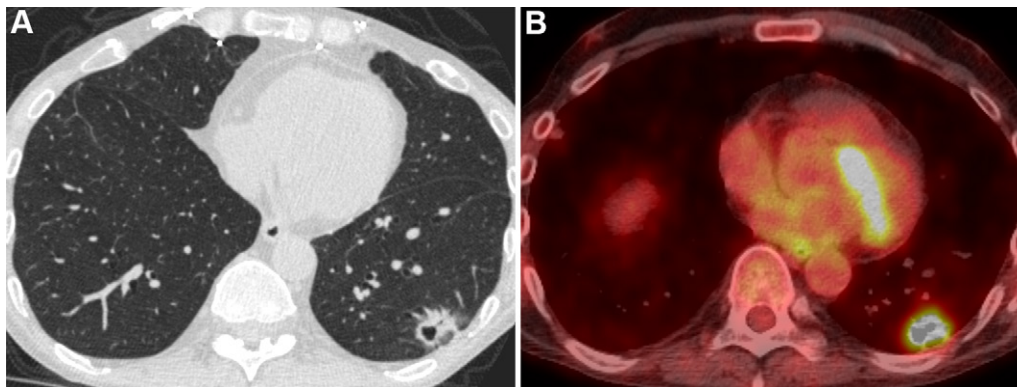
Images in a 57-year-old man with adenocarcinoma of the lung allograft 16 years after bilateral lung transplantation for idiopathic pulmonary fibrosis. (A) Axial CT image shows a left lower lobe spiculated nodule with central cavitation, and (B) axial fluorodeoxyglucose PET/CT image shows intense fluorodeoxyglucose uptake of the nodule. Biopsy proved primary adenocarcinoma of the lung.
